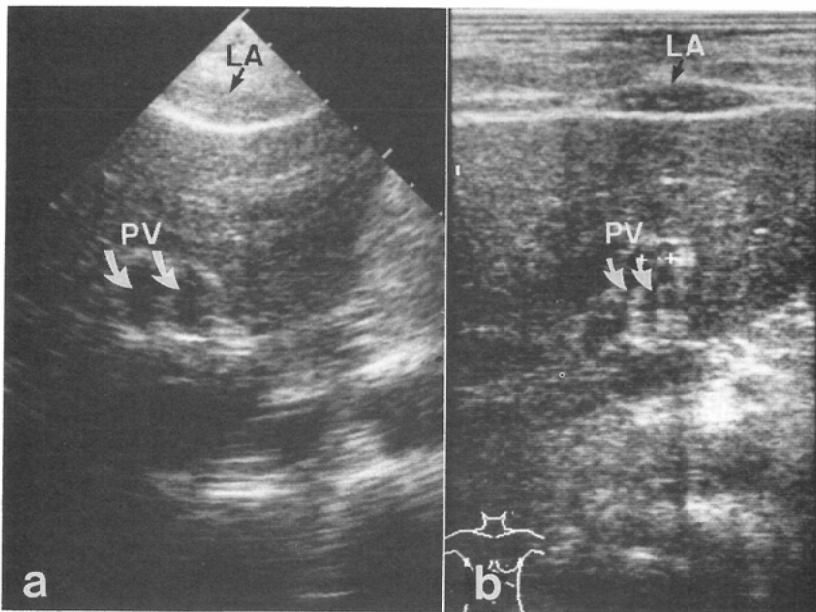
Case 6. a, A sonogram made using a phased array. b, A sonogram made using a linear array. The umbilical portion of the intrahepatic portal vein is visualized as two channels in Fig. 6a and 6b. PV=portal vein; LA=linea alba.
